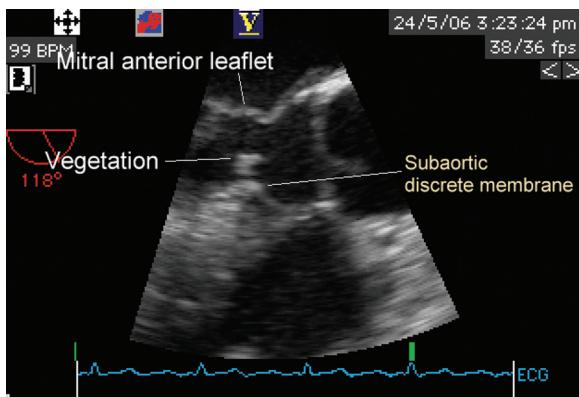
Transesophageal echocardiographic image at the aortic level demonstrating the subaortic discrete membrane and accompanying vegetation.
